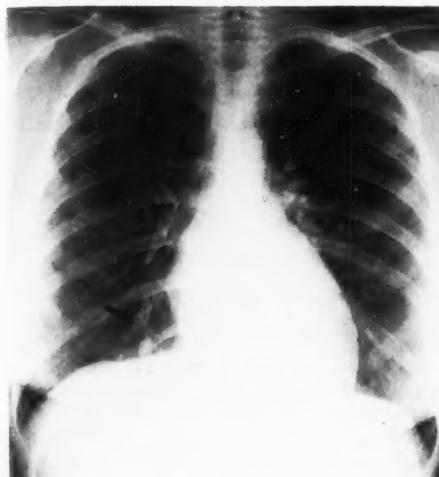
X-ray showing prominent vessel at right base
